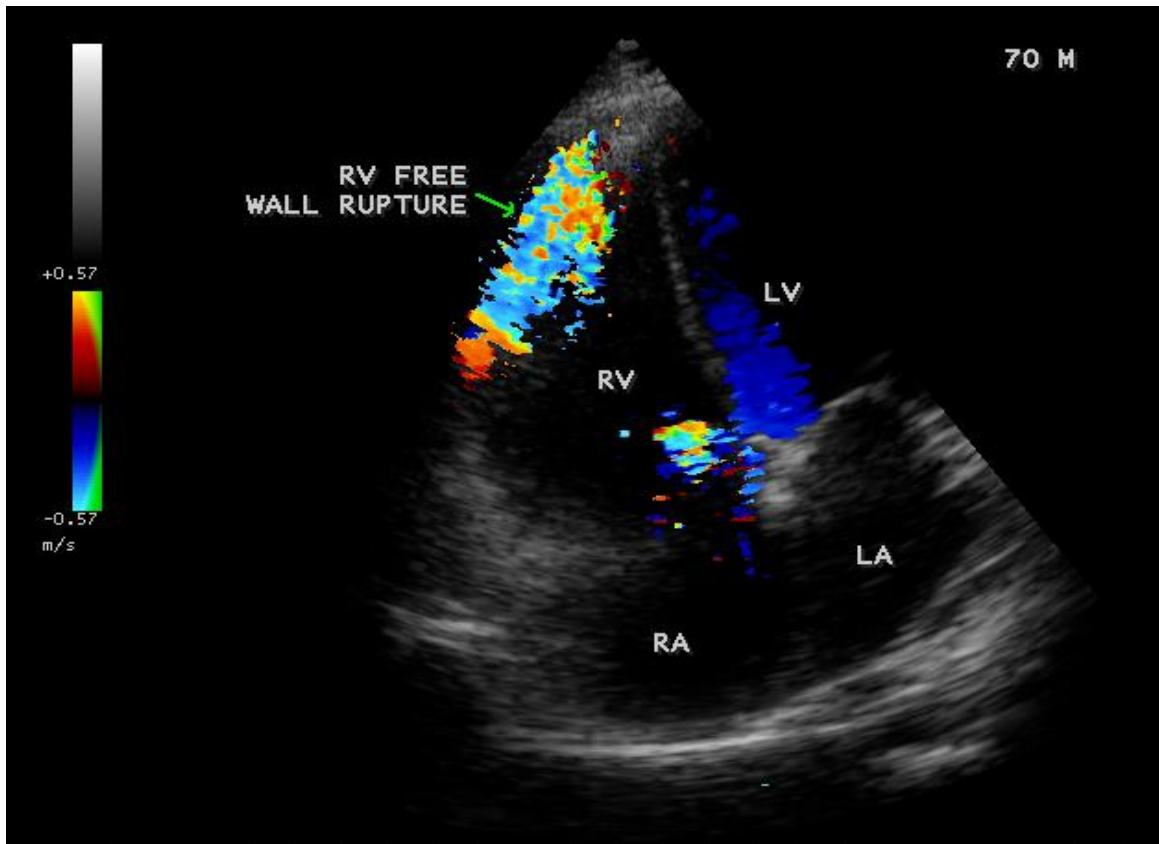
Color Doppler imaging showing the RV free wall rupture in a 70-year old male with right ventricular infarction.
